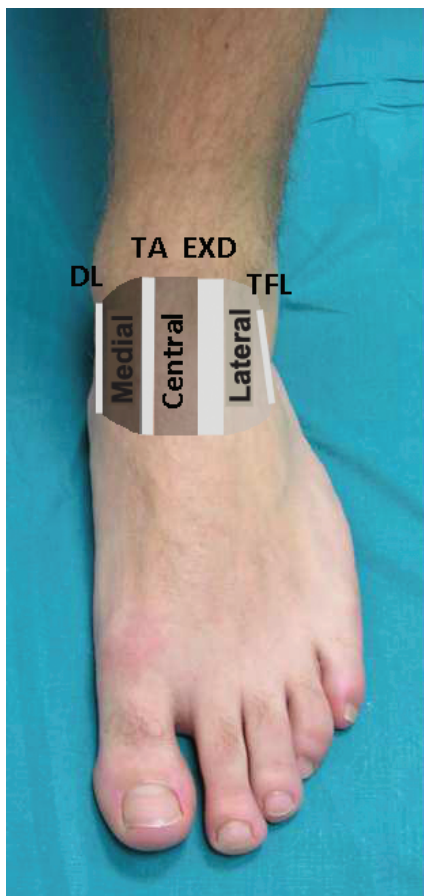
(left): Three zones are used to identify the location of the defects on ultrasound
